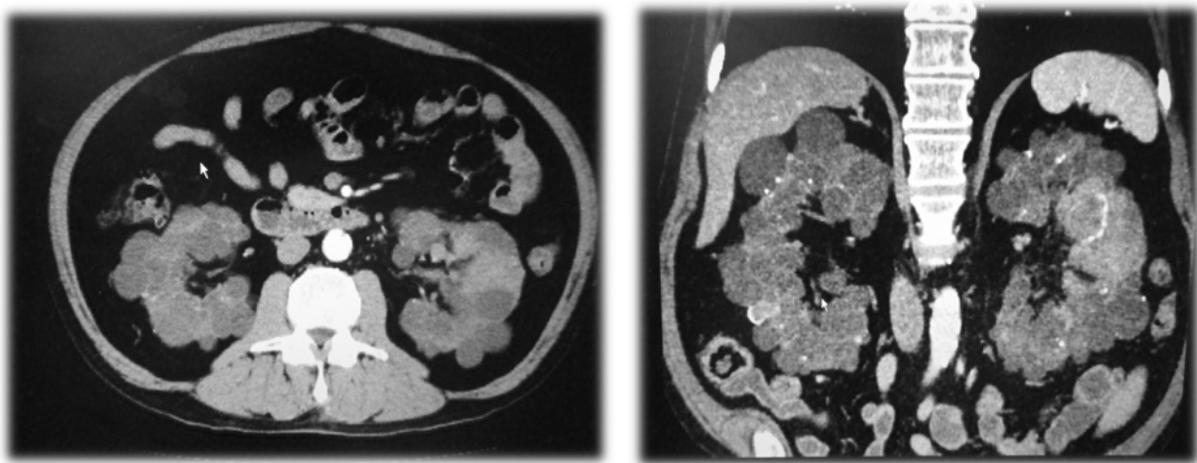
Multidetector computed tomography for ACDK-RCC. Enhanced mass was found in left kidney (Bosniak category III).
